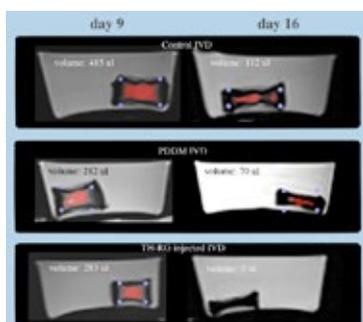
MRI segmentation of Control disc, PDDM disc and gel+cell injected discs before and after 7-day static loading.
